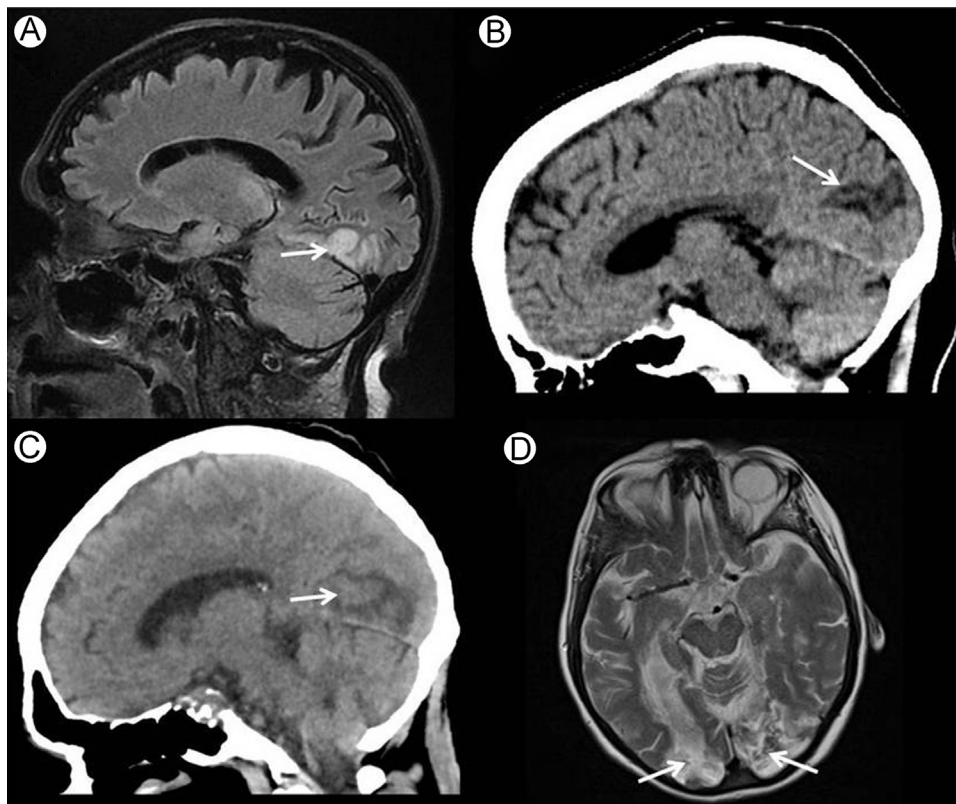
Occipital infarcts in 4 different patients: (A) sagittal FLAIR image showing inferior lip calcarine cortical infarct (arrow) in patient with superior quadrantanopia; (B) sagittal CT in a patient with an inferior quadrantanopia due to a superior lip calcarine infarct (arrow); (C) sagittal CT in a patient with homonymous hemianopia due to involvement of both superior and inferior lips of the calcarine cortex (arrow); and (D) axial T2-weighted image of a patient with cortical blindness due to bilateral infarcts of the occipital poles (arrows). CT, computed tomography; FLAIR, fluid-attenuated inversion recovery.
